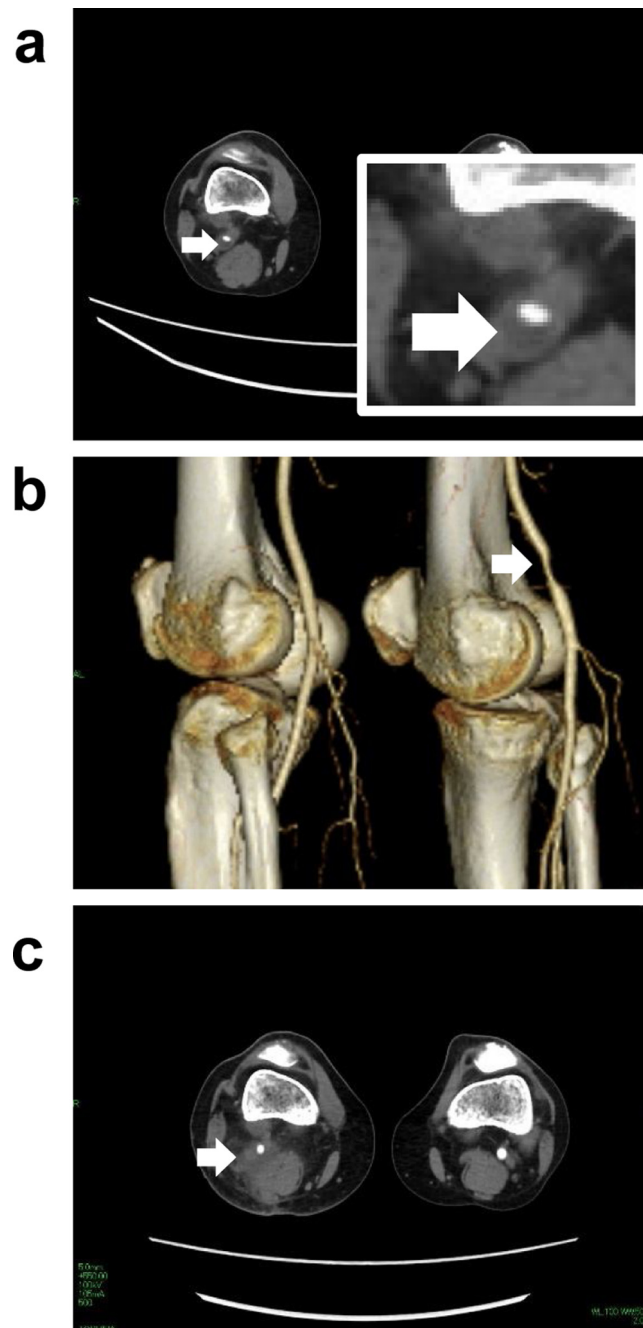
Pre- and post-operative CT scan images show pathogenesis and cure of adventitial cystic disease. (a) Preoperative axial CT image shows that the developed cystic lesion was compressing the popliteal artery of the right leg (indicated by white arrowhead). Inset, CT image enlarged at the cystic lesion. (b) Reconstituted three-dimension CT image apparently demonstrates the stenosis of the right popliteal artery (white arrowhead). (c) Postoperative CT image indicates no recurrence of the cyst (white arrowhead) six months after surgery.
